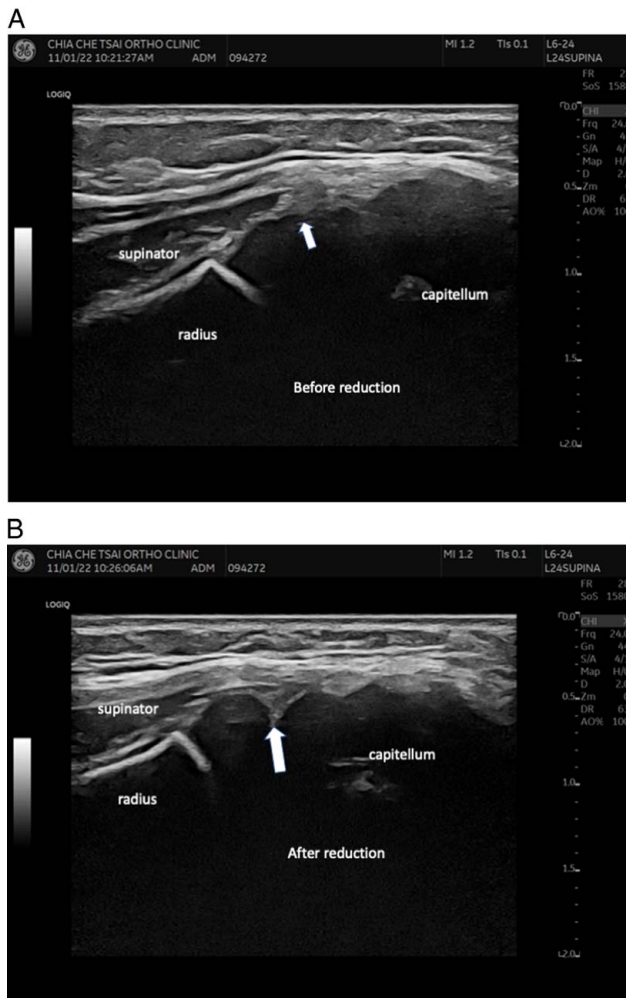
Ultrasonography of a nursemaid's elbow. Long-axis view of the radiocapitellum joint. A, Before reduction, the posterior fringe was entrapped between the radial head epiphysis and annular ligament (arrow). The distance between the radius and capitellum was not increased. B, After reduction, the normal relationship between the radial head and annular ligament returned. The escaped posterior fringe (arrow) snapped back to its normal position between the radial head and capitellum.
